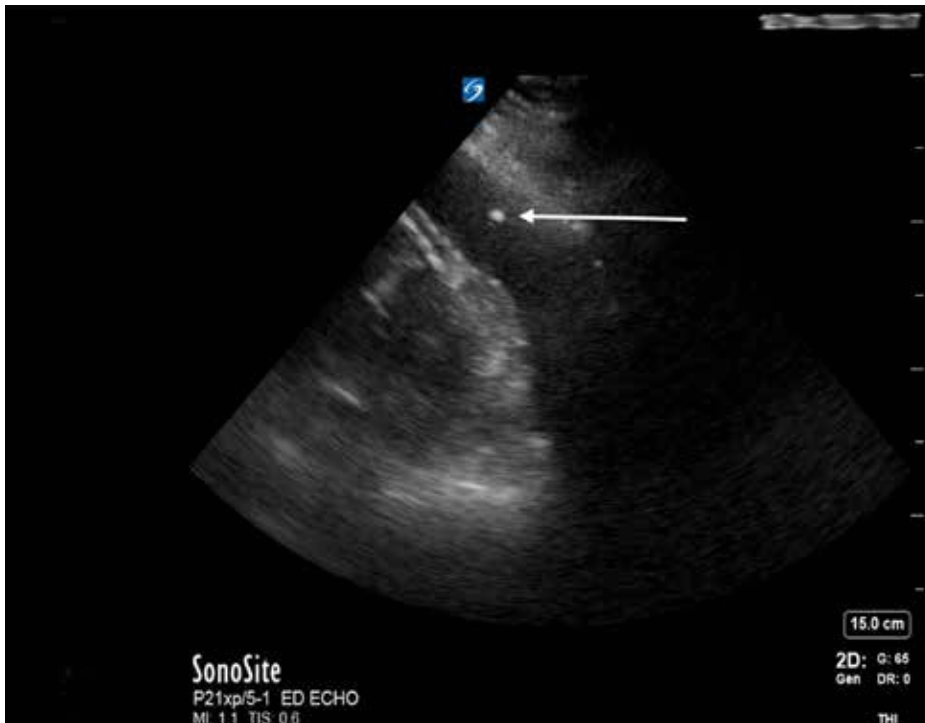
Bedside echocardiogram with spinal needle tip (white arrow) visualized in the hemopericardium during therapeutic pericardiocentesis.
